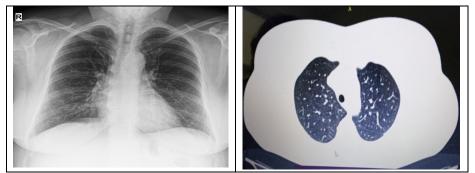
Chest X-ray: slightly thickened modifications around the hilum and in bibasal areas; pulmonary CT: disappearance of the changes in the lung parenchyma
